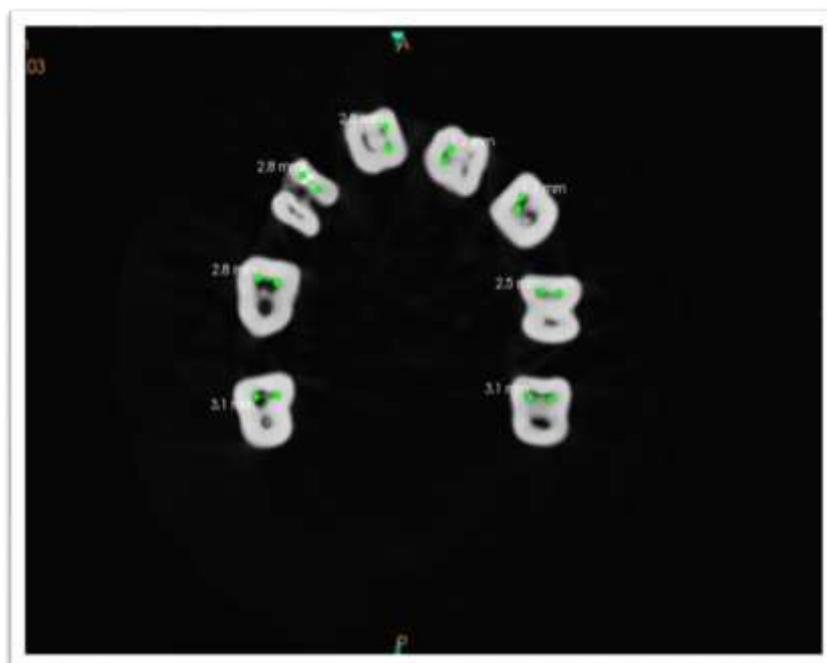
Figure represents the CBCT slice used for measuring the interorificial distance between the mesial canals in all the samples. The interorificial distances are marked at the point of furcation, at the origin of the canal from pulp space
